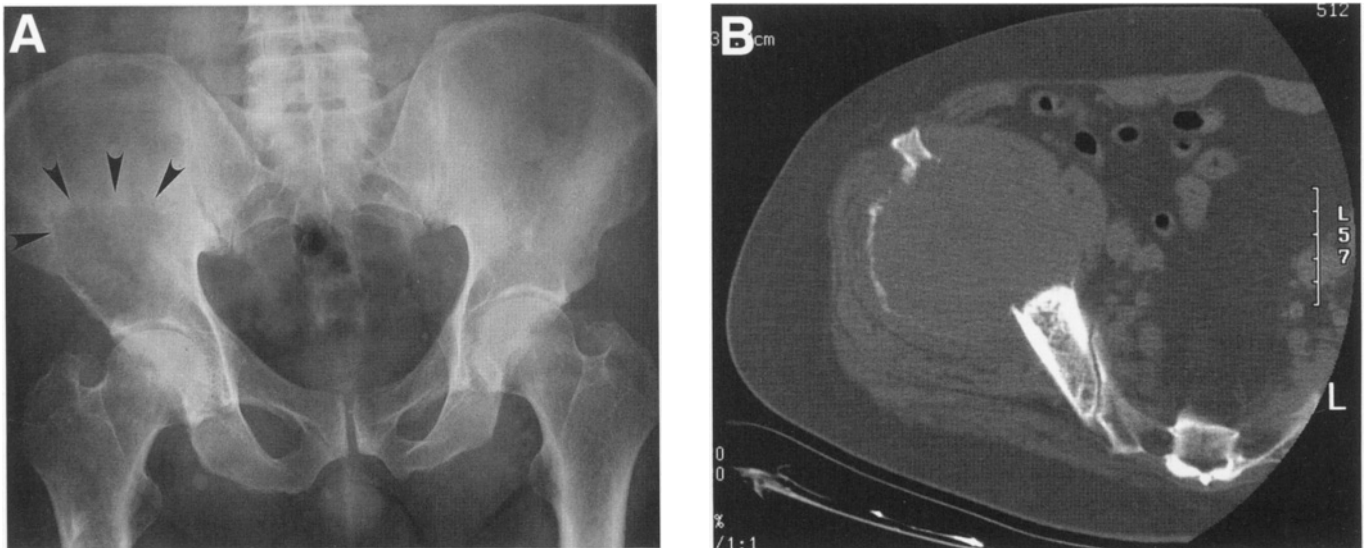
A 75-year-old patient with a 1-year history of right hip pain. Past medical history includes a subtotal thyroidectomy that was performed for an unclear diagnosis. The patient was told that the lesion was benign, and no further treatment was indicated. The patient was referred for total hip replacement and plain radiographs revealed a large lytic lesion of the right periacetabular region (A – arrows). On the basis of this radiograph one might assume that the cortices are intact. (B) CT showed extensive bone destruction and extension of the tumor to the pelvis and the right gluteal region. Complete staging demonstrated two lung metastases, and CT-guided core needle biopsy revealed a metastatic thyroid carcinoma. Following preoperative embolization the patient was treated with resection–curettage (curettage and meticulous burr drilling) and cementation.
